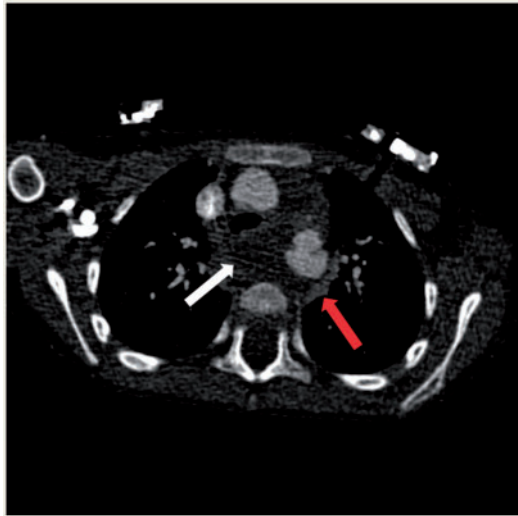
Cardiac computed tomography scan. Low attenuation peri-aortic collection (arrow) consistent with pseudoaneurysm contained by the compressive effect of the adjacent structures (tracheo-bronchial and oesophagus) with the enhanced periphery (arrow).
